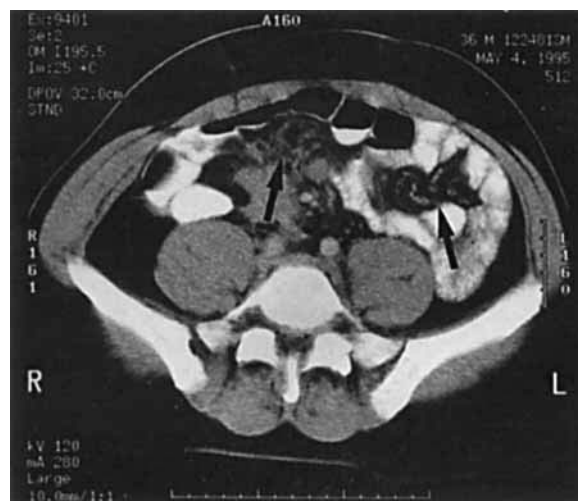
Computed tomogram showing early desmoid in the small bowel mesentery
